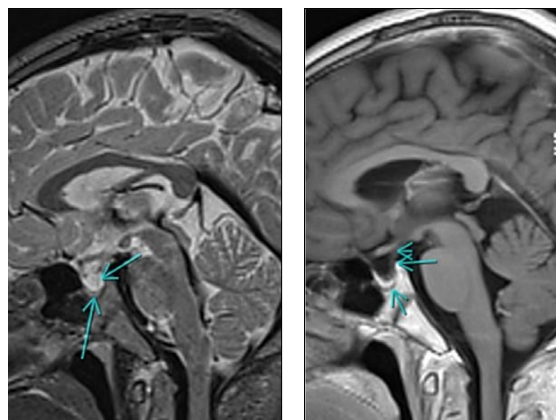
MRI findings are consistent with a grade IV empty sella, characterized by thinning of the pituitary gland and partial filling of the sella turcica with cerebrospinal fluid. The pituitary gland demonstrates homogeneous post-contrast enhancement, with no evidence of mass lesion, abnormal enhancement, or other intracranial pathology.
